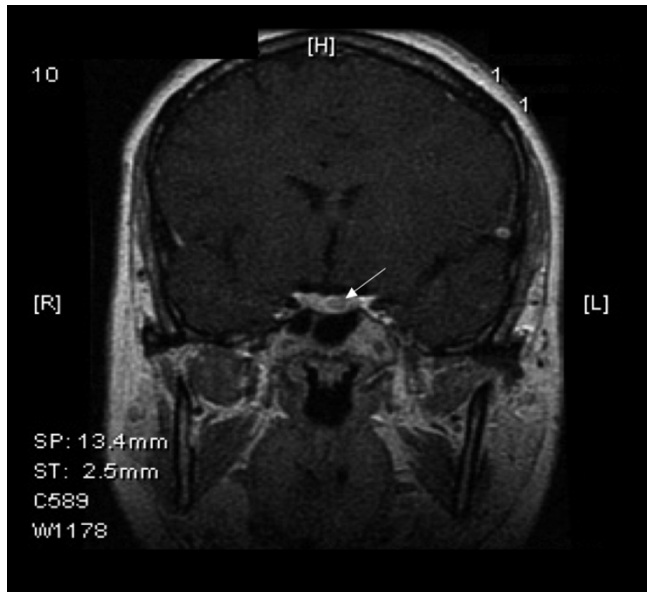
MRI scan with contrast of the brain showing a micro-adenoma pituitary gland
